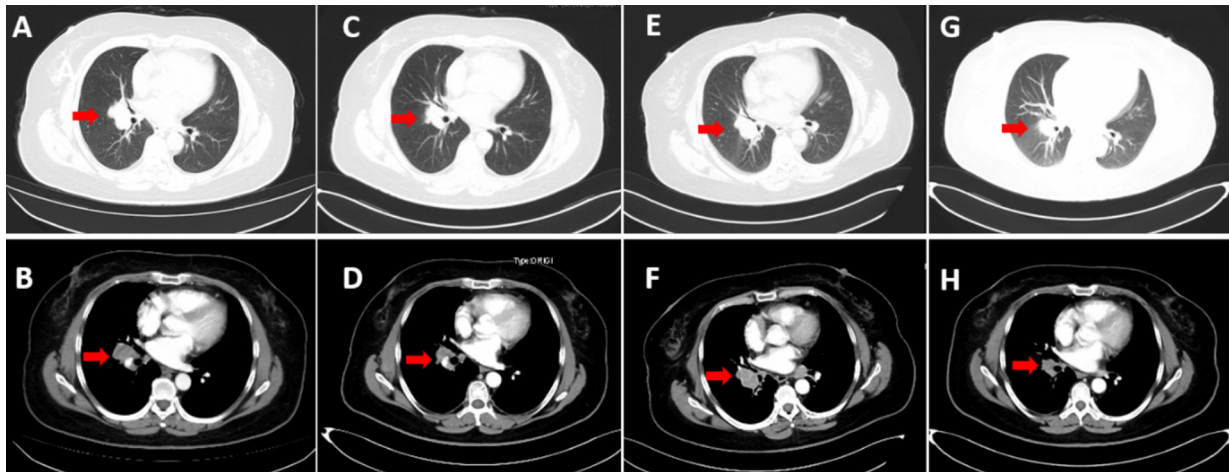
Computed tomography (CT) scan of the lungs before and after treatment. A-B, Before treatment, July 2019. C-D, After 2 cycles of pembrolizumab and chemotherapy, August 2019 (stable disease in objective response assessment). E-F, Disease progression, April 2020. G-H, After 5 cycles of treatment with gemcitabine plus cisplatin, October 2020.
